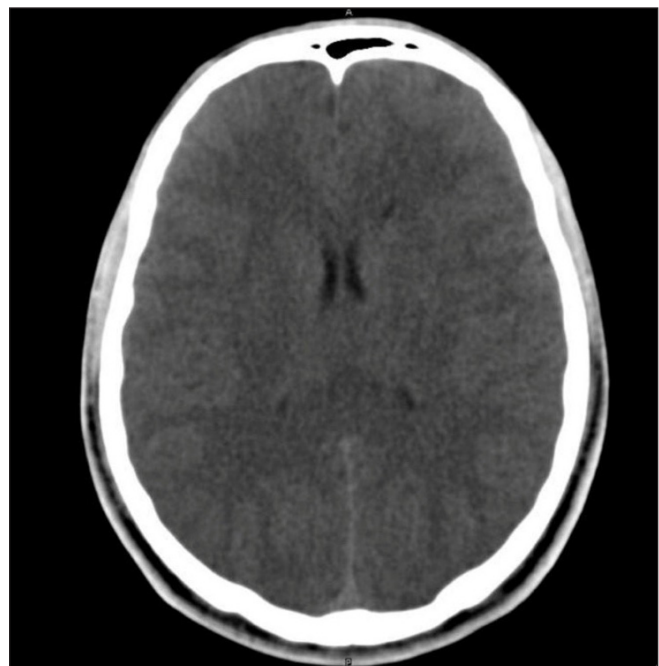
CT Scan in a patient of HACE showing absence of sulci, small ventricles, and a diffuse low-density appearance of the entire cerebrum. HACE: High-altitude cerebral edema. CT: Computed tomography
